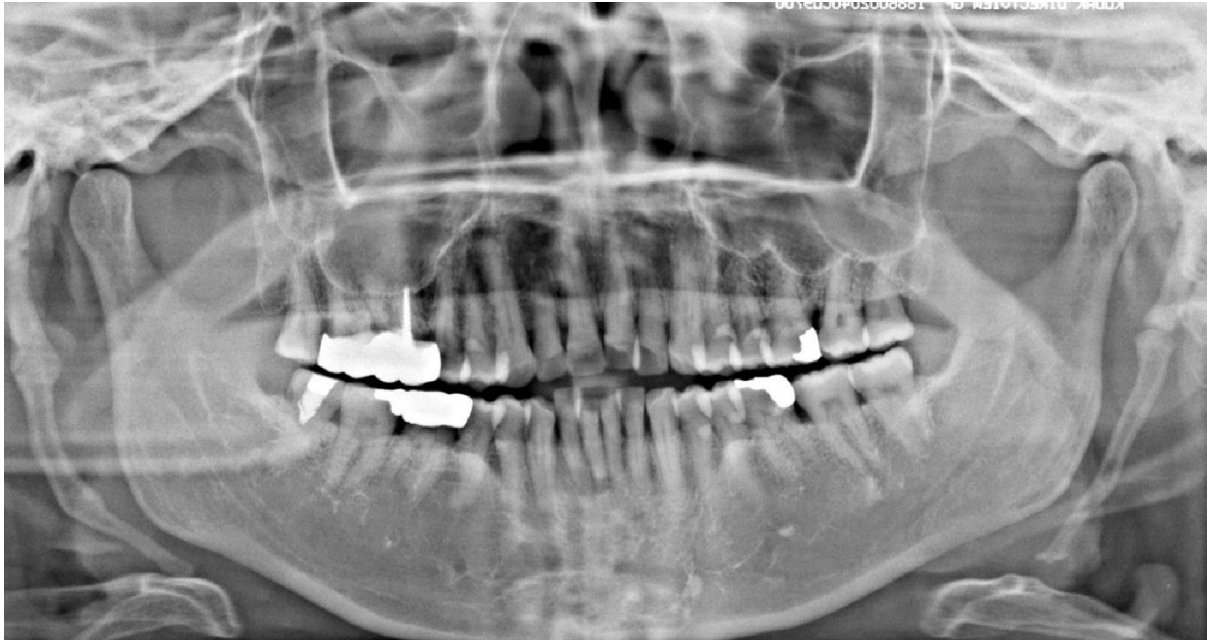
Panoramic radiograph demonstrating bilateral calcified stylohyoid ligaments.
